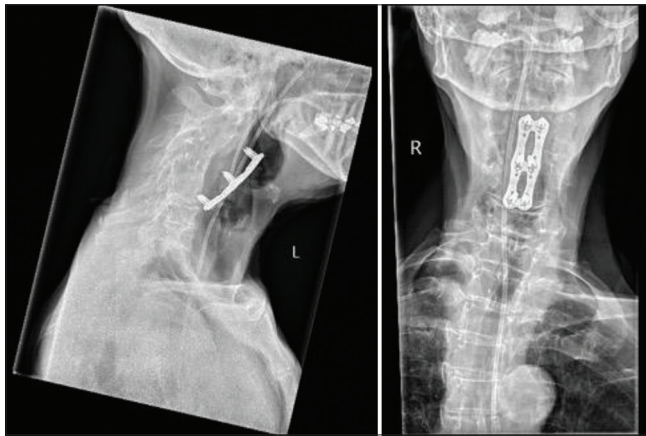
X-ray of the neck 6 years after initial neck surgery showing previous screw and plate fixation. Compared with the previous examination, the plate appears to have migrated with the superior and middle screws no longer in contact with bone on the lateral view. Unchanged advanced degenerative change and previous anterior cervical discectomy and fusion
